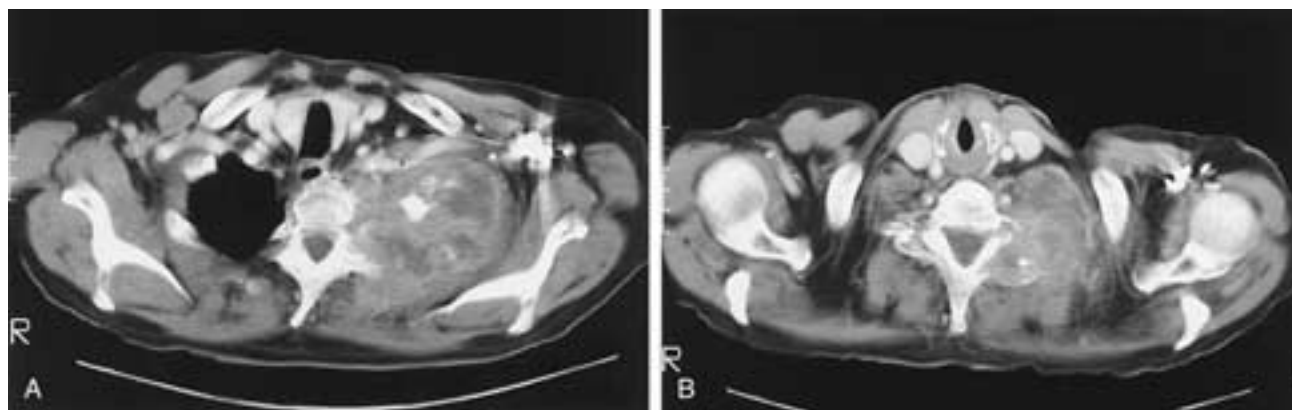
Pancoast tumor. Axial CT scan through the lung apex (A) and lower neck (B) shows a mass that extends to the posterior border of the subclavian artery (A) at the level of the thoracic inlet. This lesion encases the scalene muscles in the neck.
